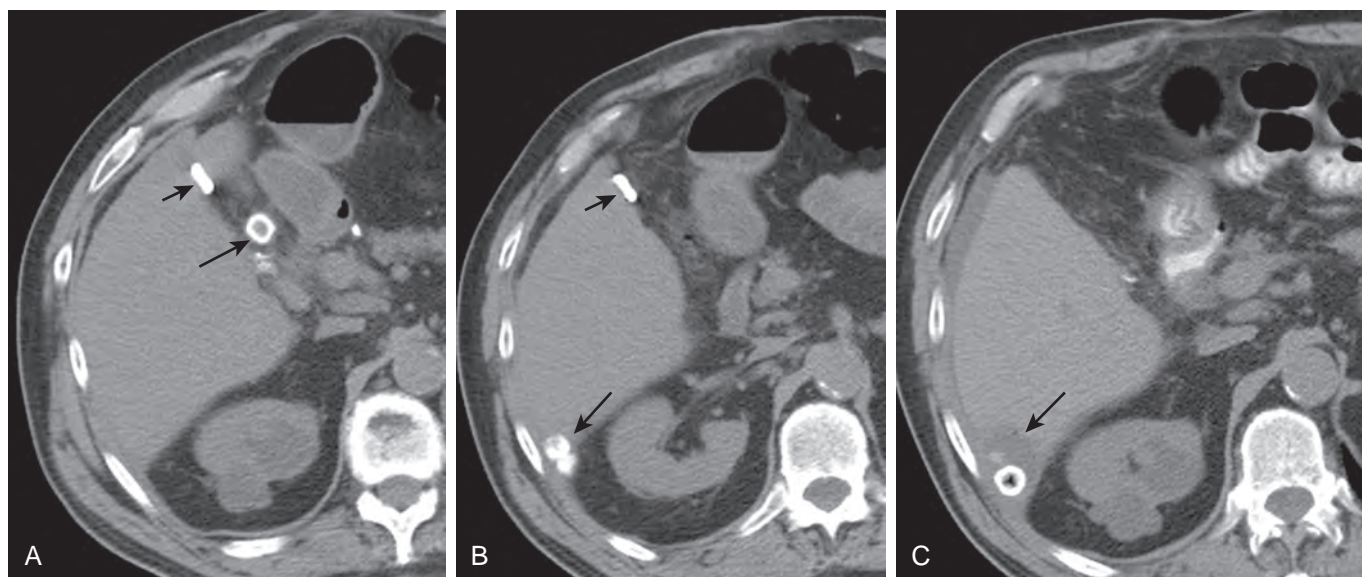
Spilled gallstones resulting in perihepatic abscess. A and B. Noncontrast CT 3 days after LC shows a dropped gallstone in the porta hepatis (*long arrow, A*) and two dropped gallstones in Morison's pouch (*arrow, B*). Note surgical clip (*short arrow*) in gallbladder fossa. C. Patient presented 4 weeks after LC with fever and abdominal pain. Noncontrast CT shows interval development of an abscess surrounding the two dropped gallstones in Morison's pouch (*arrow*) and free fluid around the liver.
